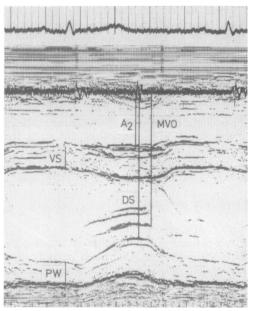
M mode echocardiogram of a patient with mild hypertension (blood pressure 165/105 mm Hg) without evidence of hypertrophy of the posterior wall (PW) or septum (VS) showing delay in the timing of mitral valve opening (MVO) from minimum cavity dimension (DS) and prolonged isovolumic relaxation.
